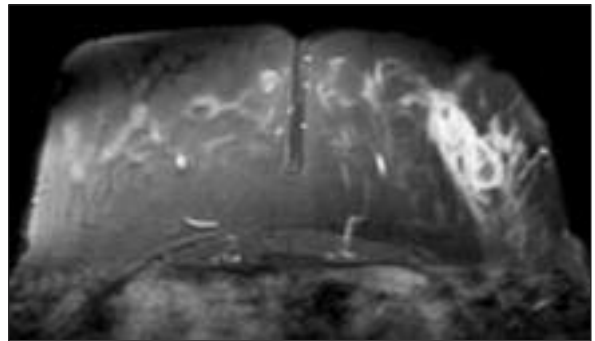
Heterogeneously enhancing areas and ring-like enhancement of abscess are seen on postcontrast MRI of the patient in Figure 7a.
